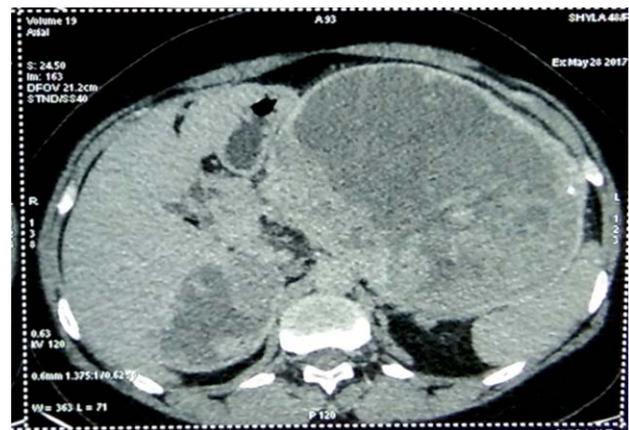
Abdominal computed tomography (CT) examination of the patient. This abdominal CT image shows bilateral adrenal mass (left > right)
